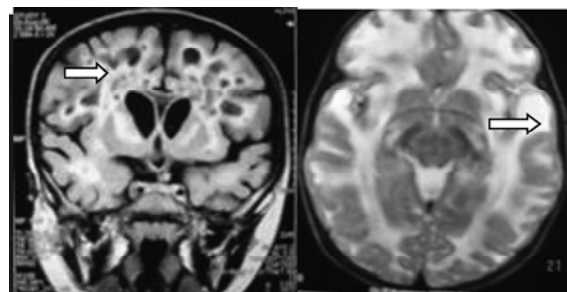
Vanishing White Matter disease Coronal FLAIR shows diffuse white matter involvement with cystic changes Fig.52.Vander Knapp disease Axial T2 MR image showing diffuse white matter involvement with cyst in the anterior temporal pole
